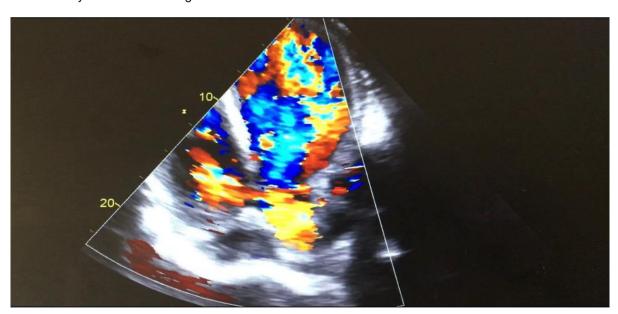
Apical 5-chamber echocardiographic section with color Doppler showing restrictive perimembranous interventricular septal defect associated with severe aortic leak forming Laubry- Pezzi syndrome
